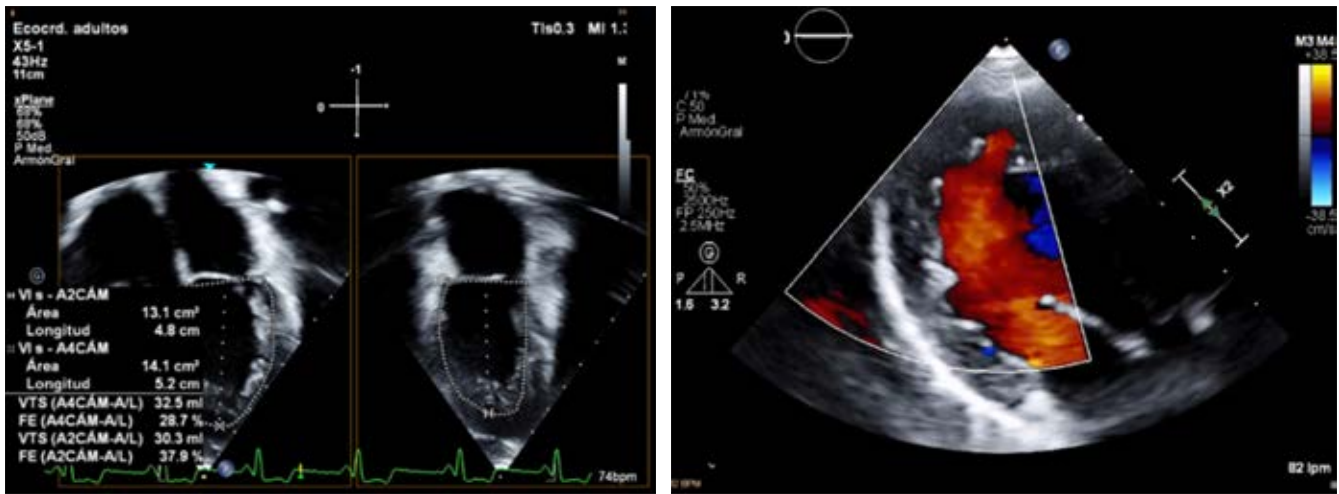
Postoperative echocardiogram showing improvement in left ventricular function after pulmonary artery banding. LVEF A/L 37.9%.
